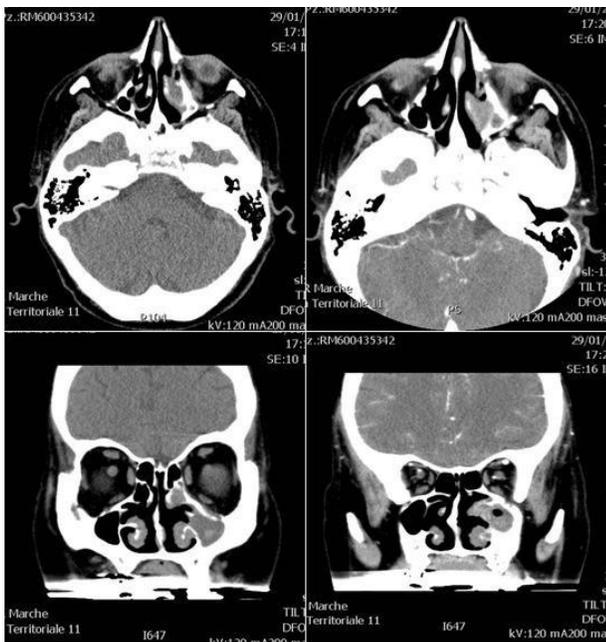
CT: significant reduction of the mass (2.2 x 1.2 x 1.5 cm). The bony orbital floor appears slightly thickened and demineralized.
